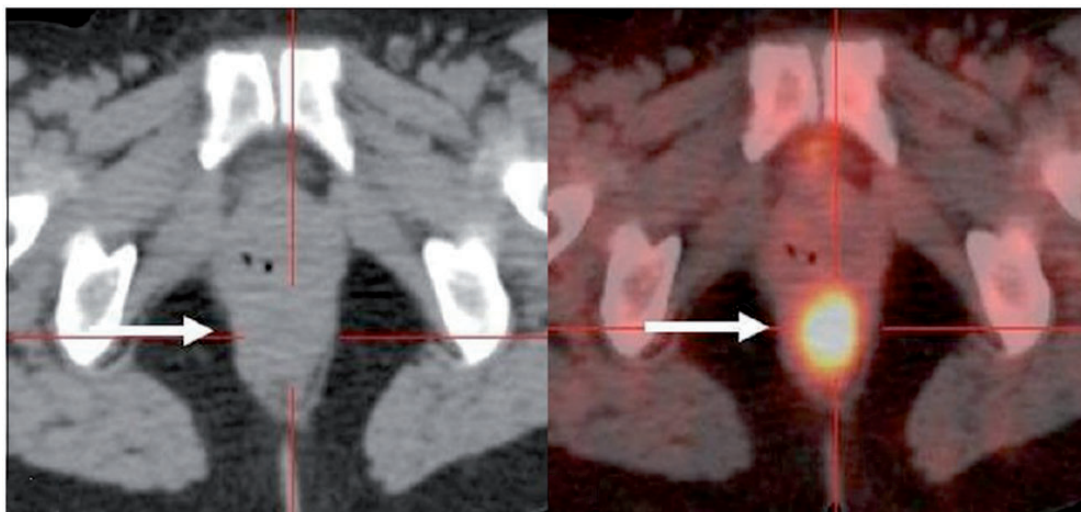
Axial unenhanced CT scan (left) shows ill-defined soft-tissue thickening in the perianal region (arrow) without definite evidence of a nodule/mass. Fusion PET/CT image (right) shows an intense focus of hypermetabolism corresponding to the soft-tissue thickening, suggesting rectal cancer, which can help the radiation oncologist to define the GTV^[48].
